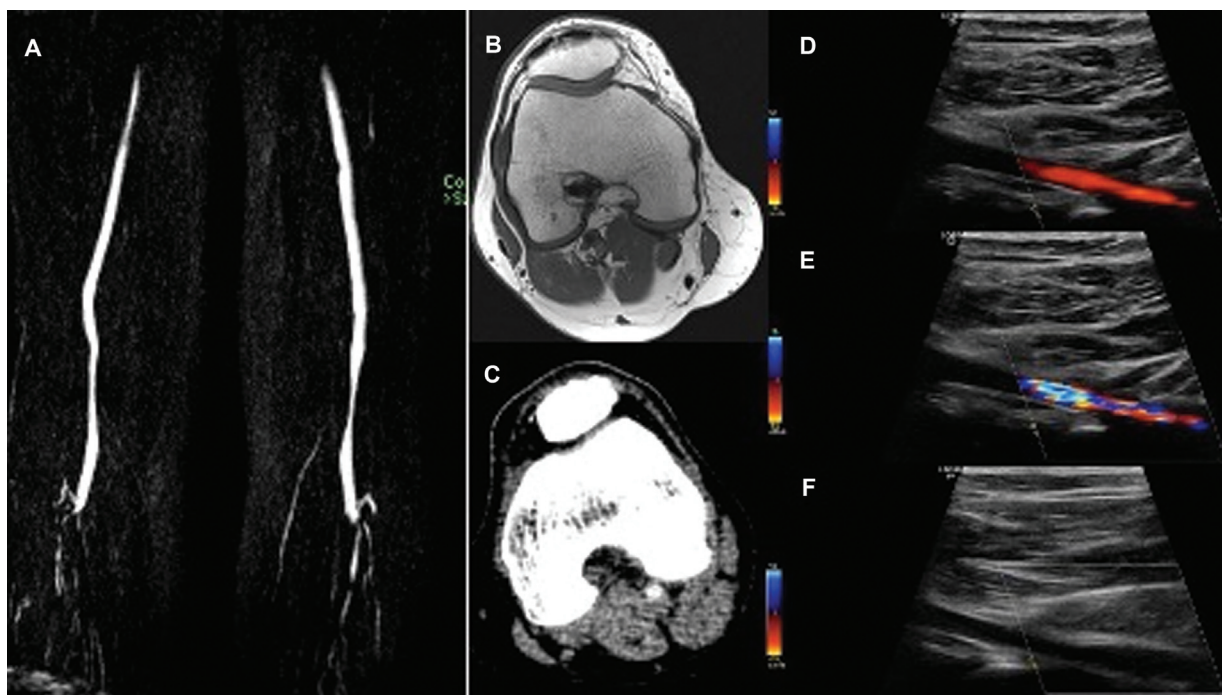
Functional popliteal artery entrapment syndrome (fPAES, type VI): The patient was referred to the hospital with an ultrasound diagnosis of bilateral PAES. However, the patient was symptomatic on the left side only. Noncontrast magnetic resonance angiography curved maximum-intensity projection image (A) showing patent popliteal arteries at respective popliteal fossa floors. T1-weighted axial image (B) and axial computed tomography angiogram (C) showing no occlusion or aberrant muscle compressing onto the popliteal artery. The conundrum was solved by the use of dynamic ultrasound reproducing exertion. Long-axis color Doppler image of the popliteal artery approximately 4 cm proximal to the anterior tibial artery in resting position (D) showing no occlusion, during plantar flexion (E) showing mild flow resistance evident by flow turbulence and mild reduction in arterial diameter. There was a complete lack of popliteal artery flow during resisted forced plantar flexion (F) consistent with functional PAES.
